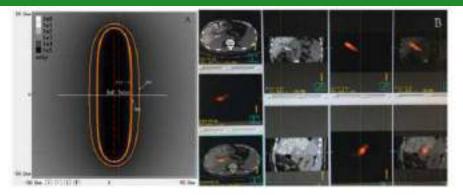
Images of dosimetry of a lodine-125 seeds strand and SPECT/CT. A. Desimetry of a seed strand containing 16 Indine-125 seeds. The indexe contours are: 100% (82.5%), reference point, red dot), 90% (36.2%), and 80% (31.2%). The 240 day mecomplation dose warl41.5%. B. Image of a SPECT/CT scan performed 1 day after the procedure. Spect and 1-125 seed strands were implanted correctly in the MPV without displacement. Radiation emitted by a 1-125 seed strand was distributed homogeneously and completely covered the tay.
